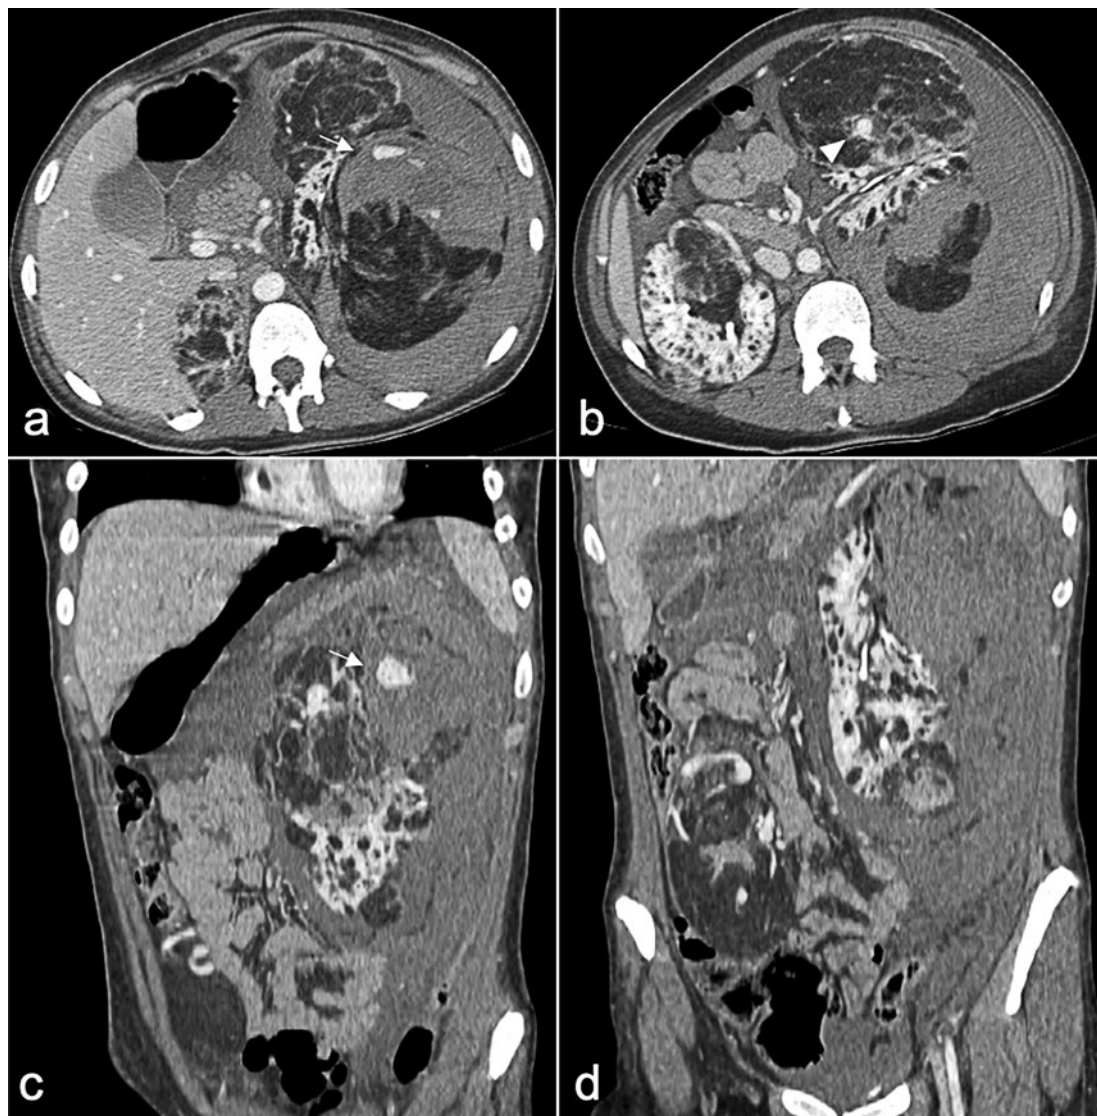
Contrast-enhanced computed tomography (CT) shows an exophytic superior renal pole, well-enhanced giant angiomyolipoma (AML) characterized by 18 cm of longitudinal diameter, with massive retroperitoneal hematoma and active bleeding (*arrows; a,c*) from left renal tumor. (*b*) The tumor, in the ventral lateral position in the left kidney, also contains microaneurysms (*arrowhead*). (*d*) Coronal reconstruction better defines longitudinal extension of AML.
